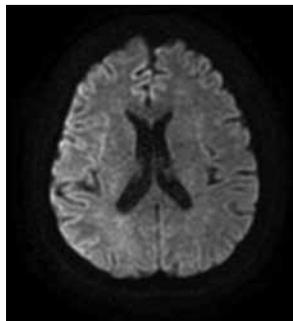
A mild increase in diffusion in the white matter lesions can be seen in the diffusion-weighted MR images.
